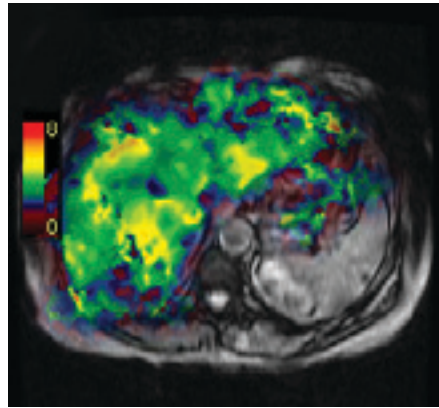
MRI with elastogram.
